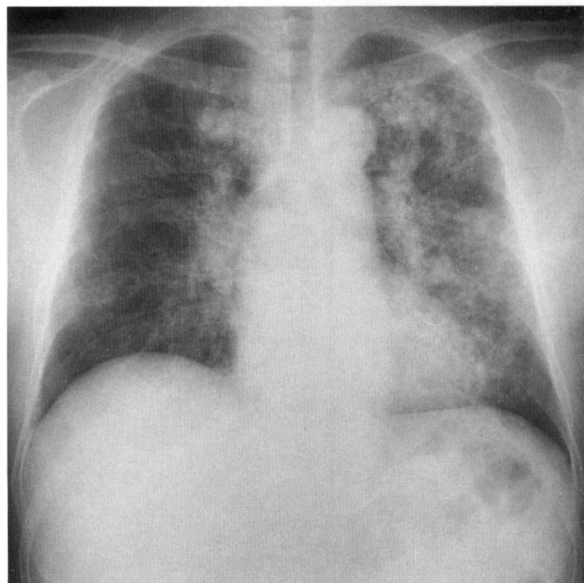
Chest radiograph obtained on the day before open lung biopsy. Note bilateral multiple patchy areas of consolidation predominantly distributed at left lower lung.
